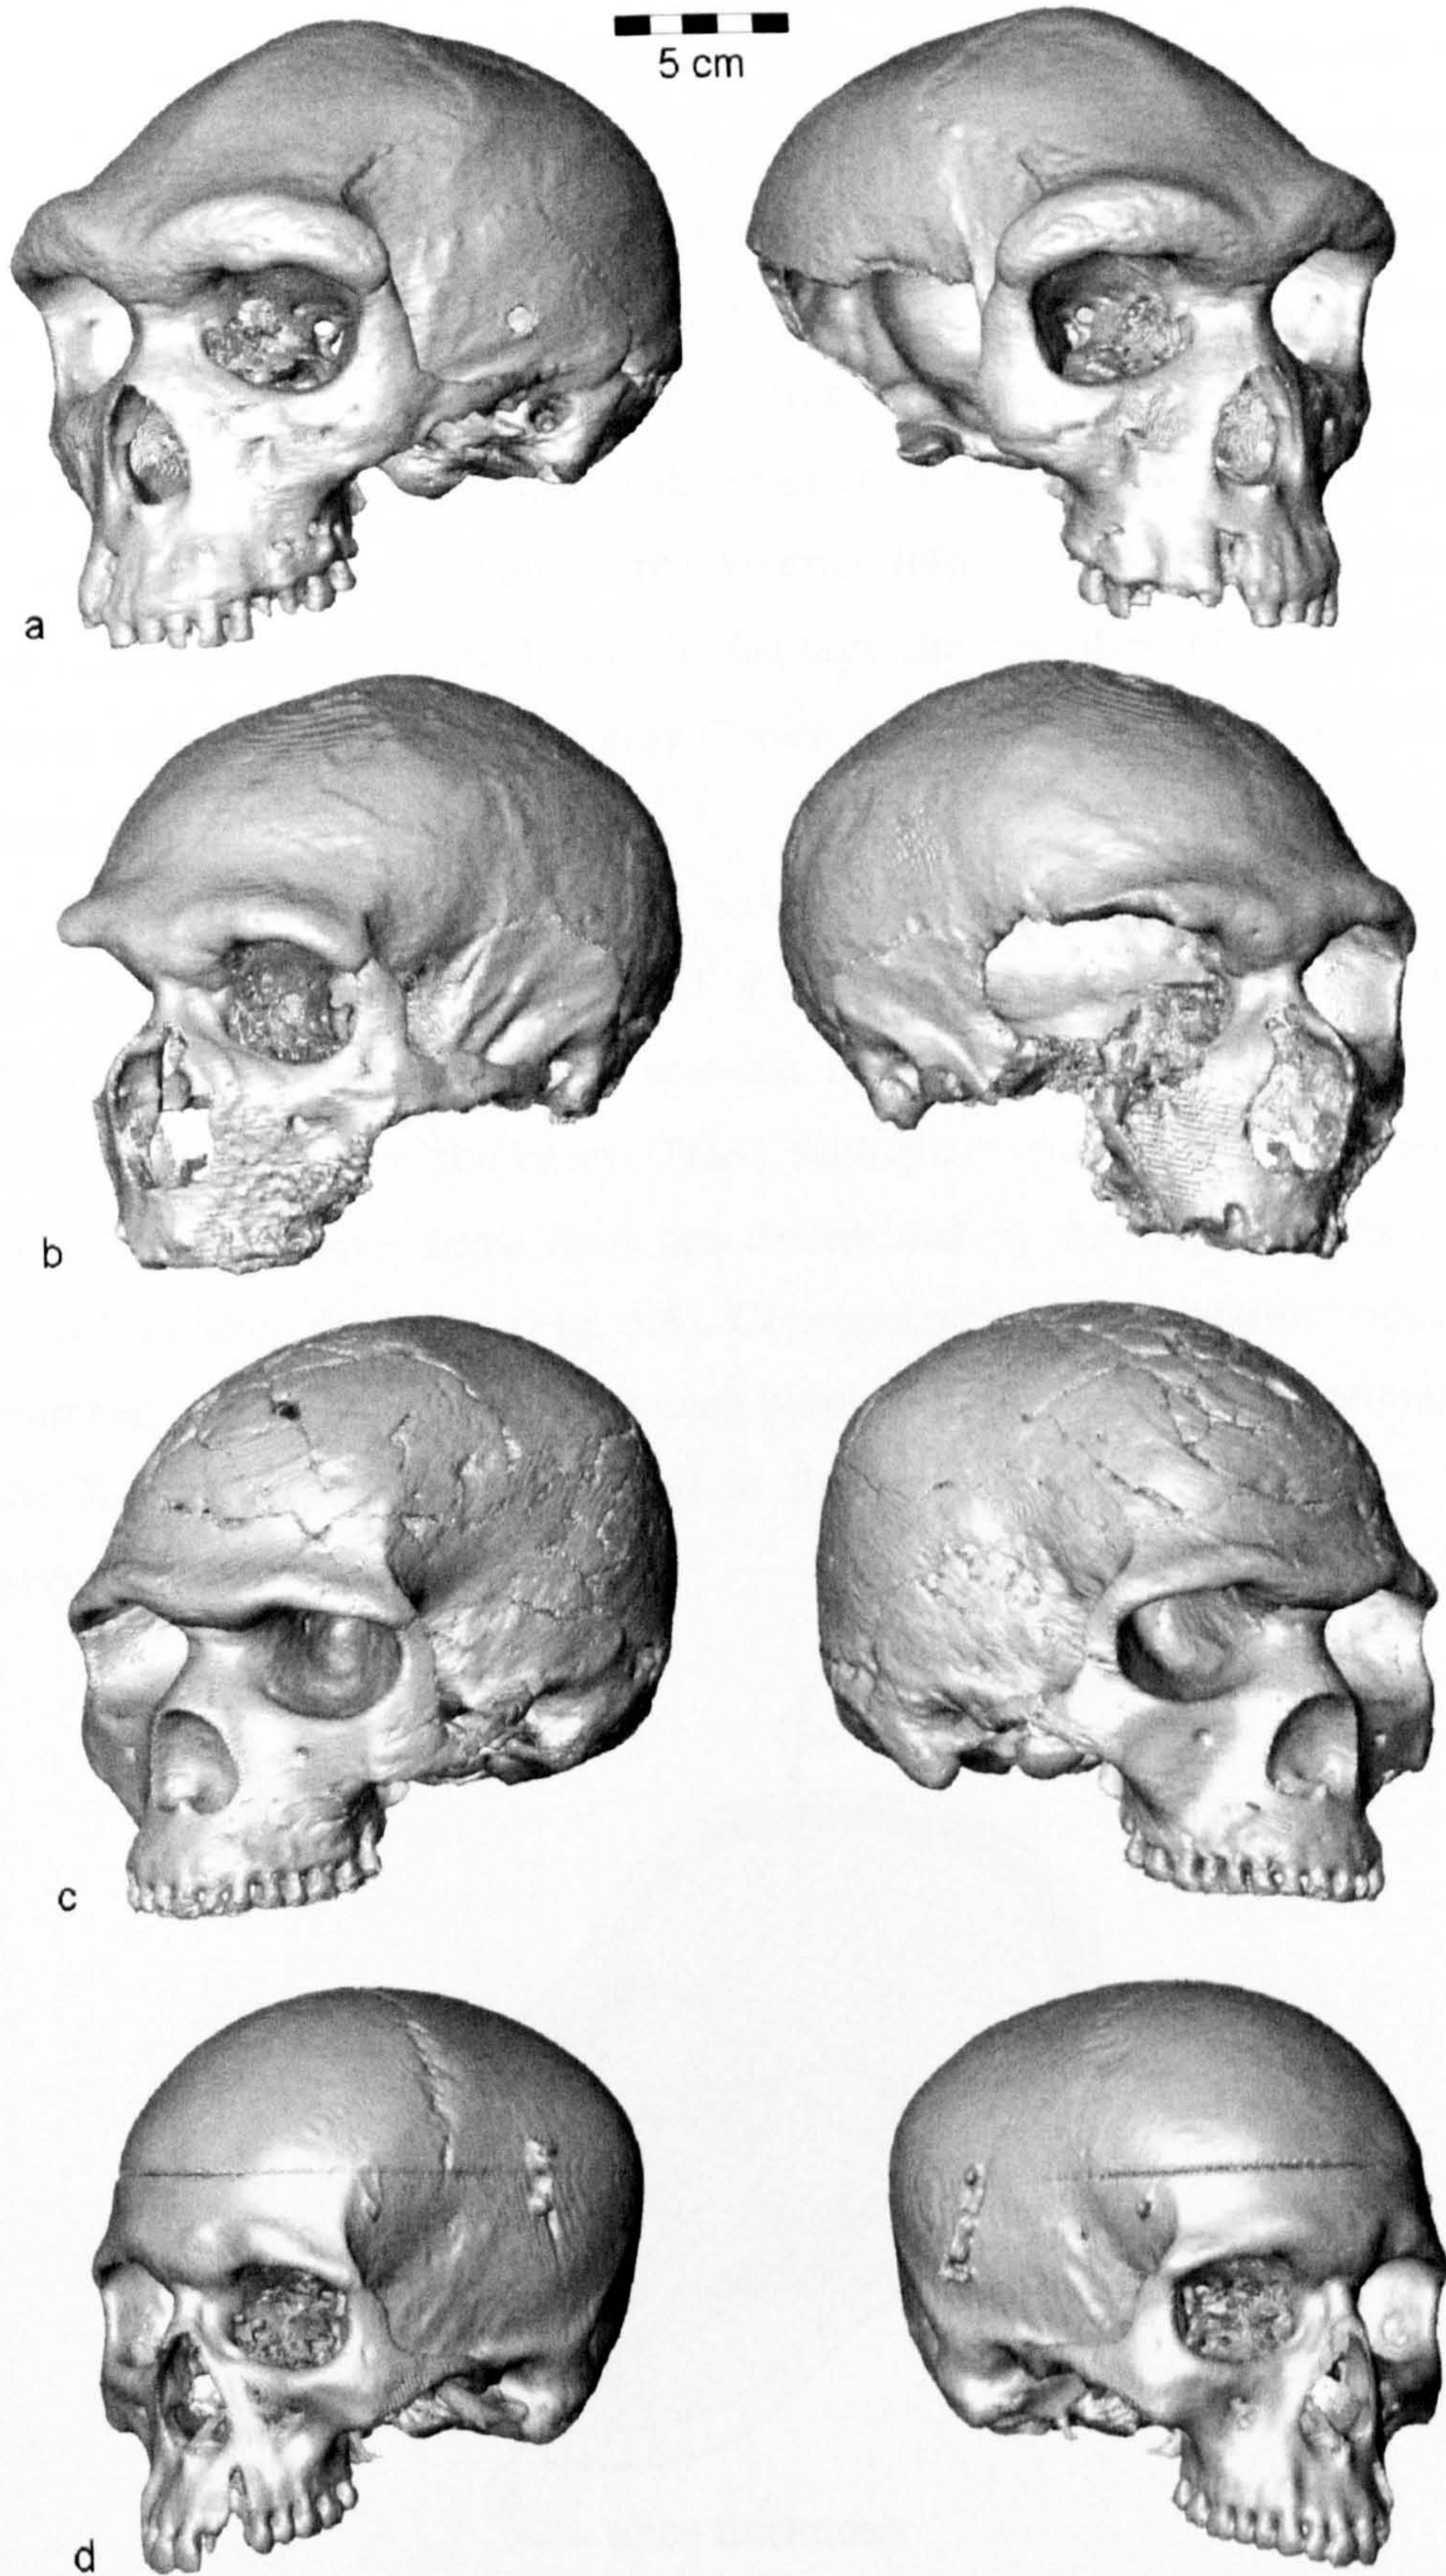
CT-based 3D models of the crania used in this study: a) Kabwe 1, b) Guattari 1, c) Skhul 5, d) ANAT 800.
